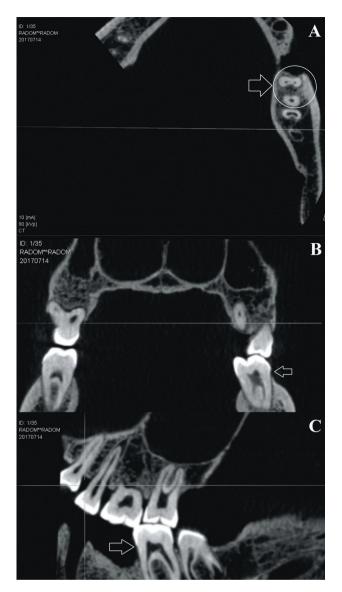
Images of cbct with marked root canals in the first permanent lower molar: a – axial scan (two canals in the mesial root and one canal in the distal root), b – coronal scan (two canals in the mesial root), c – sagittal scan (mesial and distal root).
